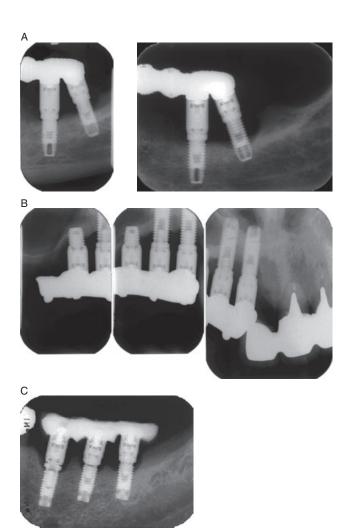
(A) Radiographs showing two fixtures (V2 and V3) 1 and 2.5 years, respectively, after bridge attachment and indicating progressive marginal bone loss around V3 causing mucosal disorder and resulting in the removal of fixture V3 6 months later. (B) Radiographs 7 years after bridge attachment showing a fractured (after 2 years) and repaired implant (H3) and a newly fractured implant (H2). After repairing H2, all fixtures functioned another year until H3 and H2 had to be removed with implant H1, which had then lost its osseointegration. (C) Radiograph 17 years after bridge attachment showing fractures of two implants (V2 and V3) and of one abutment screw (V1). V2 and V3 could not be repaired and had to be removed.
